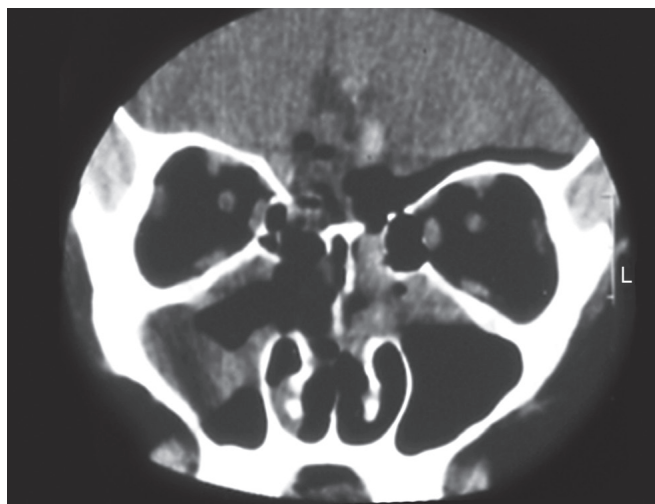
Computed tomography (CT) scan of catastrophic complication and front lobe injury.
